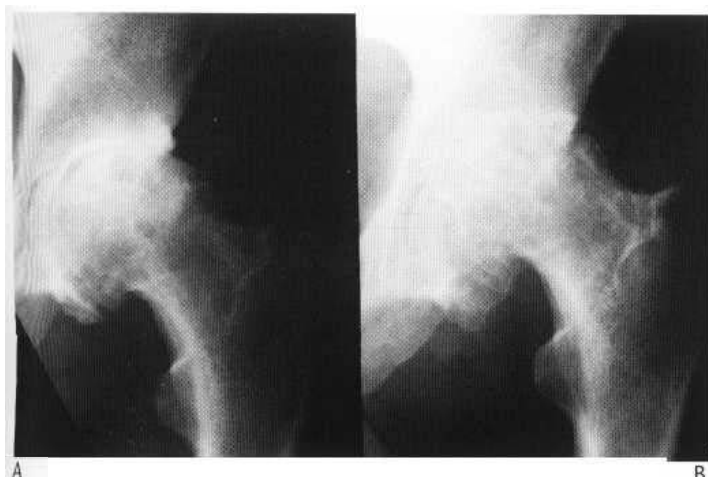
(A) The initial radiograph shows lateral migration of the femoral head with obliteration of the superior joint space. There is accretion of new bone medially within the joint. (B) The subsequent radiograph shows collapse of the femoral head and of the acetabulum. There is now more new bone both on the femoral head and on the acetabulum medially. A new joint space often results. Buttressing of the medial cortex of the femoral neck (the calcar) is a common finding in degenerative disease of the hip.
